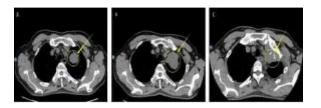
Re-examination of CT. A: After 2 months of afatinib treatment, CT showed that the mass in the left upper lung was reduced (4.5×3.9 cm), but it was increased after 4 months of Afatinib treatment (B, 5.2×4.4 cm). Then, after 2 months of treatment with camrelizumab, the mass was significantly decreased (C, 3.9×2.7 cm)
